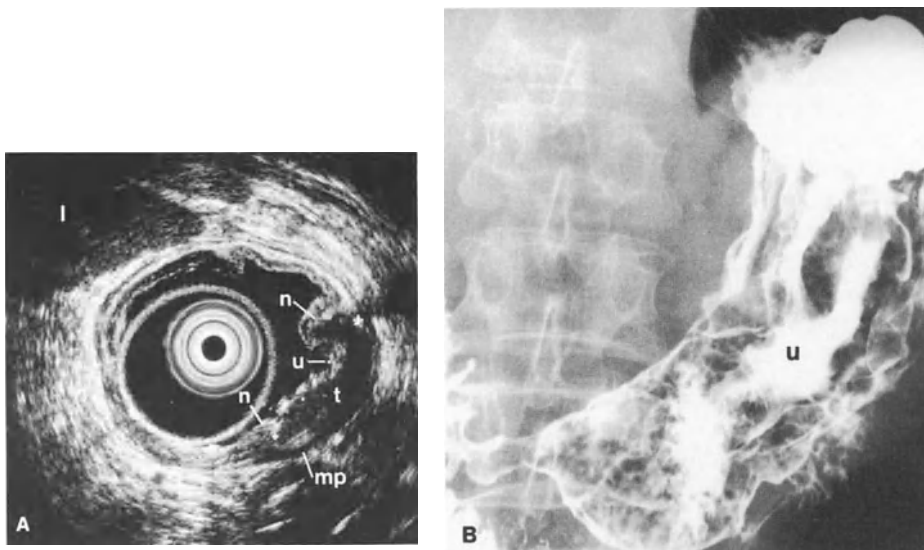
A Endoscopic sonogram showing sharply demarcated hypoechoic tumor (*t*) penetrating into the muscularis propria (*mp*) directly adjacent to an ulcer (*u*) with nodular margins (*n*). *l*, left liver lobe. B Corresponding radiogram, showing the ulcer (*u*) localized at the greater curvature of the stomach
